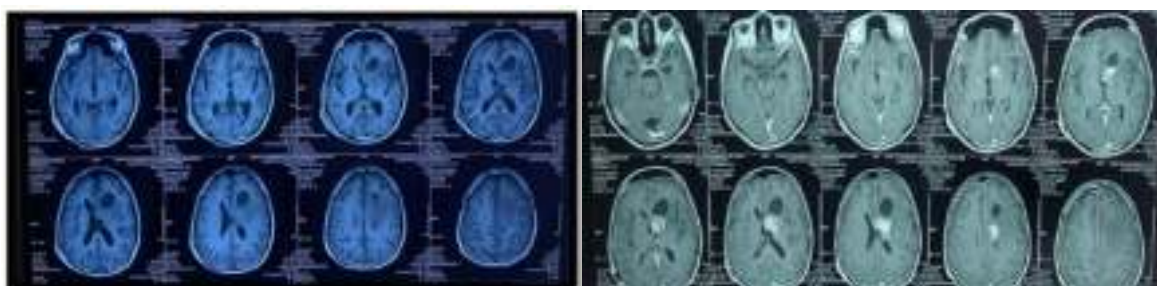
Brain MRI Patients After 2 Cycle Chemotherapy.
